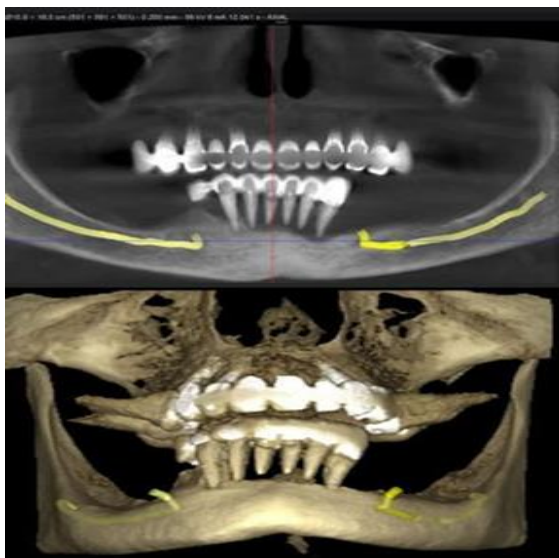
Preoperative clinical and CBCT evaluation demonstrating severe mandibular alveolar ridge deficiency and inadequate bone volume for implant placement.
